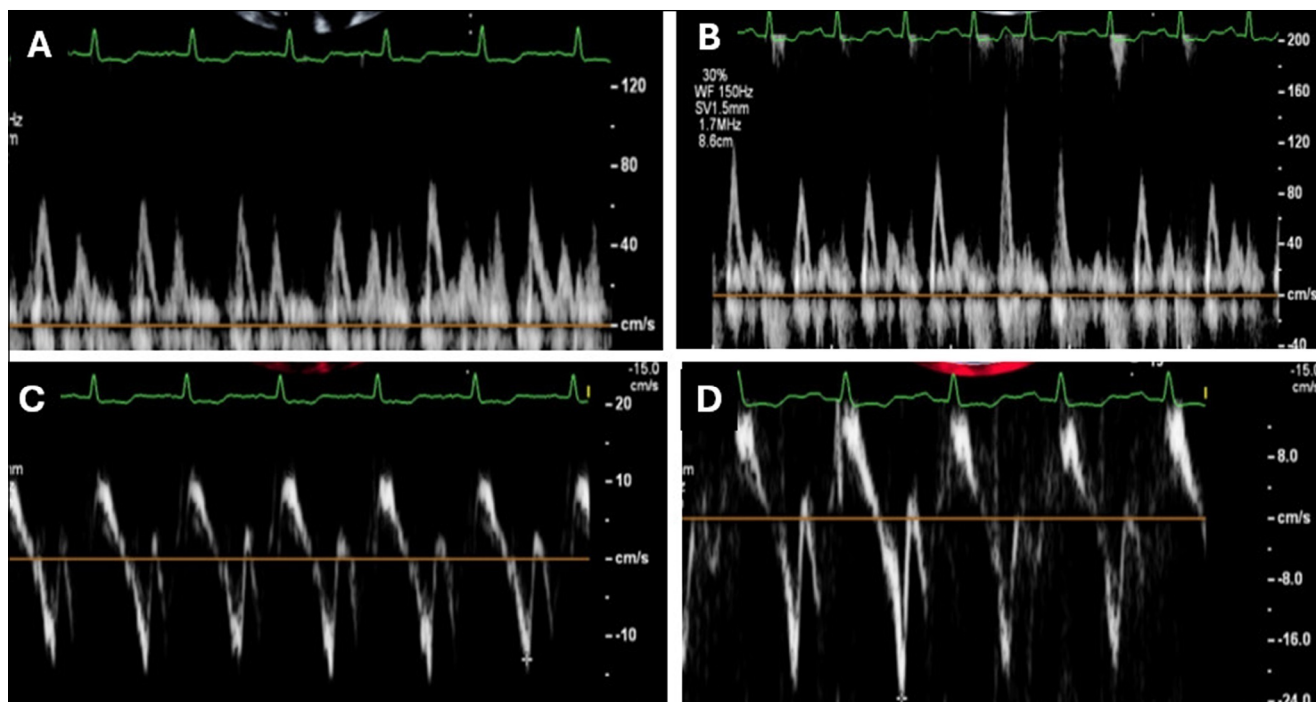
Exercise Doppler echocardiogram with demonstration of worsening constrictive physiology. Mitral inflow at rest with minimal respiratory variation (A) with significant inflow variation following exercise (B). Mitral septal e' with exaggerated values at rest (C; 0.13 m/s), increasing post-exercise (D; 0.23 m/s).
